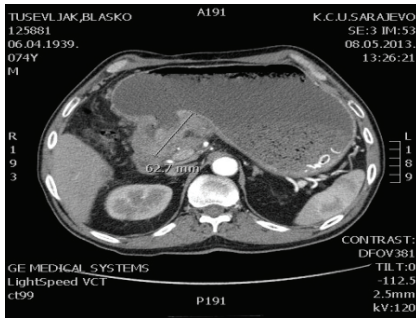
CT image of a stomach tumor process
